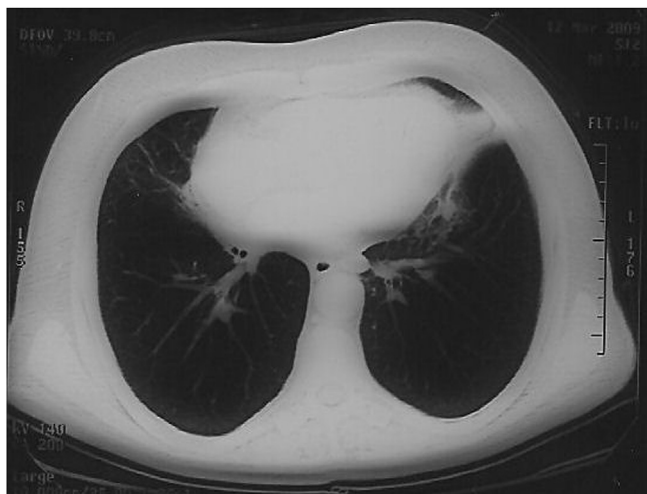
Patient Thorax CT after Chemotherapy [2].
